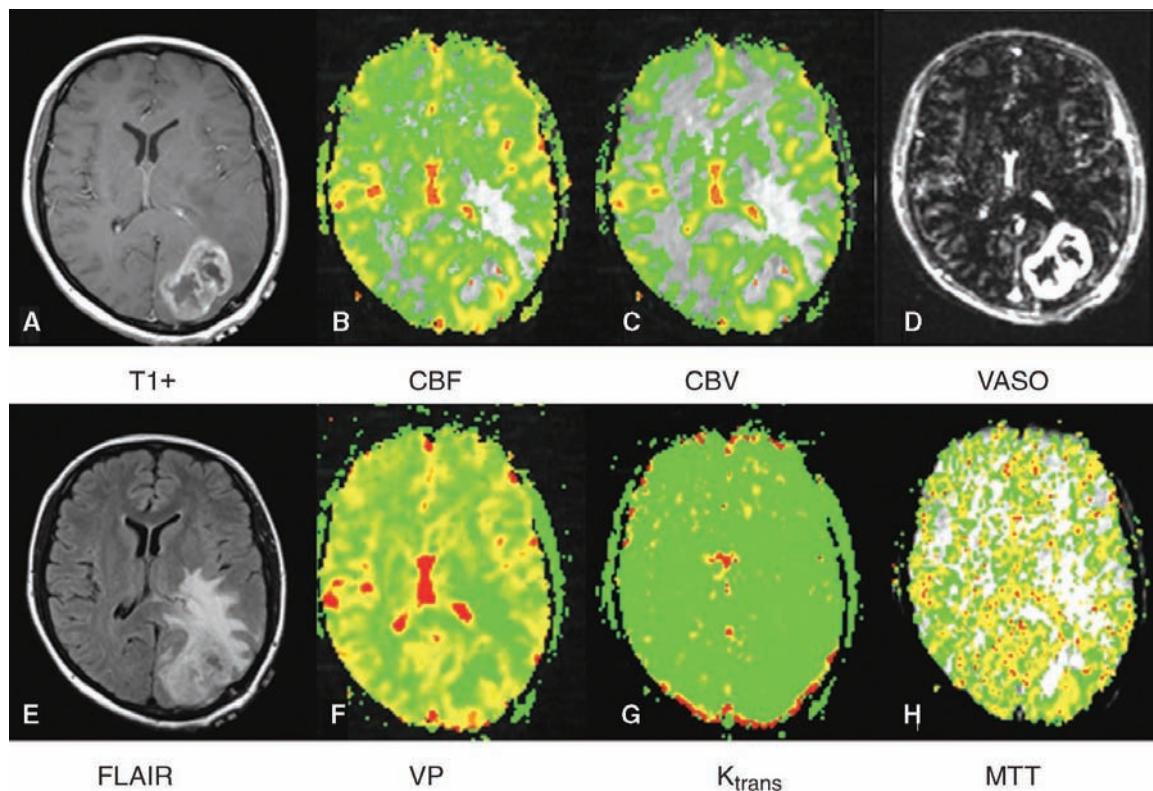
Pathologically proven left parieto-occipital high-grade glioma. (A) Axial T1-weighted postgadolinium image. (B/C) Gradient-echo axial DSC MRI, CBF, and CBV overlay images demonstrating increased CBF and CBV. (D) Vasoperfusion image also confirming that there is increased perfusion within left parieto-occipital lesion. (E) Axial FLAIR image demonstrating increased signal surrounding the left parieto-occipital lesion. (F/G/H) Gradient-echo axial DSC MRI with V_p , K^{trans} , and MTT color overlay demonstrates an increase in V_p , K^{trans} and MTT. Abbreviations: FLAIR, fast fluid-attenuated inversion recovery; DSC MRI, dynamic susceptibility contrast MRI; CBF, cerebral blood flow; CBV, cerebral blood volume; V_p , blood plasma volume; K^{trans} , vascular permeability; MTT, mean transit time. Source: From Ref. 112.
